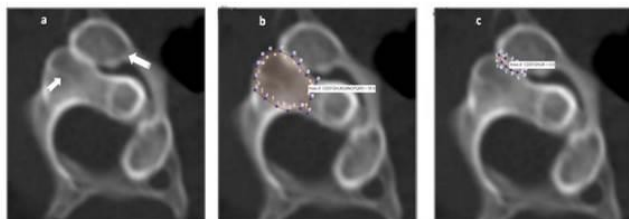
(a) CT scan, axial view, with the patient's head rotated maximally to the left. The notched arrow points to the right superior articulating facet of C2, and the striped arrow points to the right inferior articulating facet of C1. (b) The same scan as in Figure 2a, with the outer margin of the right superior articulating facet of C2 outlined using the GeoGebra software, resulting in an area of 18.9 cm². (c) The same scan as depicted in Figure 2a and b, but with the residual overlapping area of C1 and C2 outlined using the GeoGebra software, resulting in an area of 0.9 cm². The area of residual overlap, as a percent of the total area of the superior articulating facet of C2, is calculated as $(0.9/18.9 \times 100\%)$, and is thus 4.8%. (R—right, L—left, A—anterior, P—posterior).
